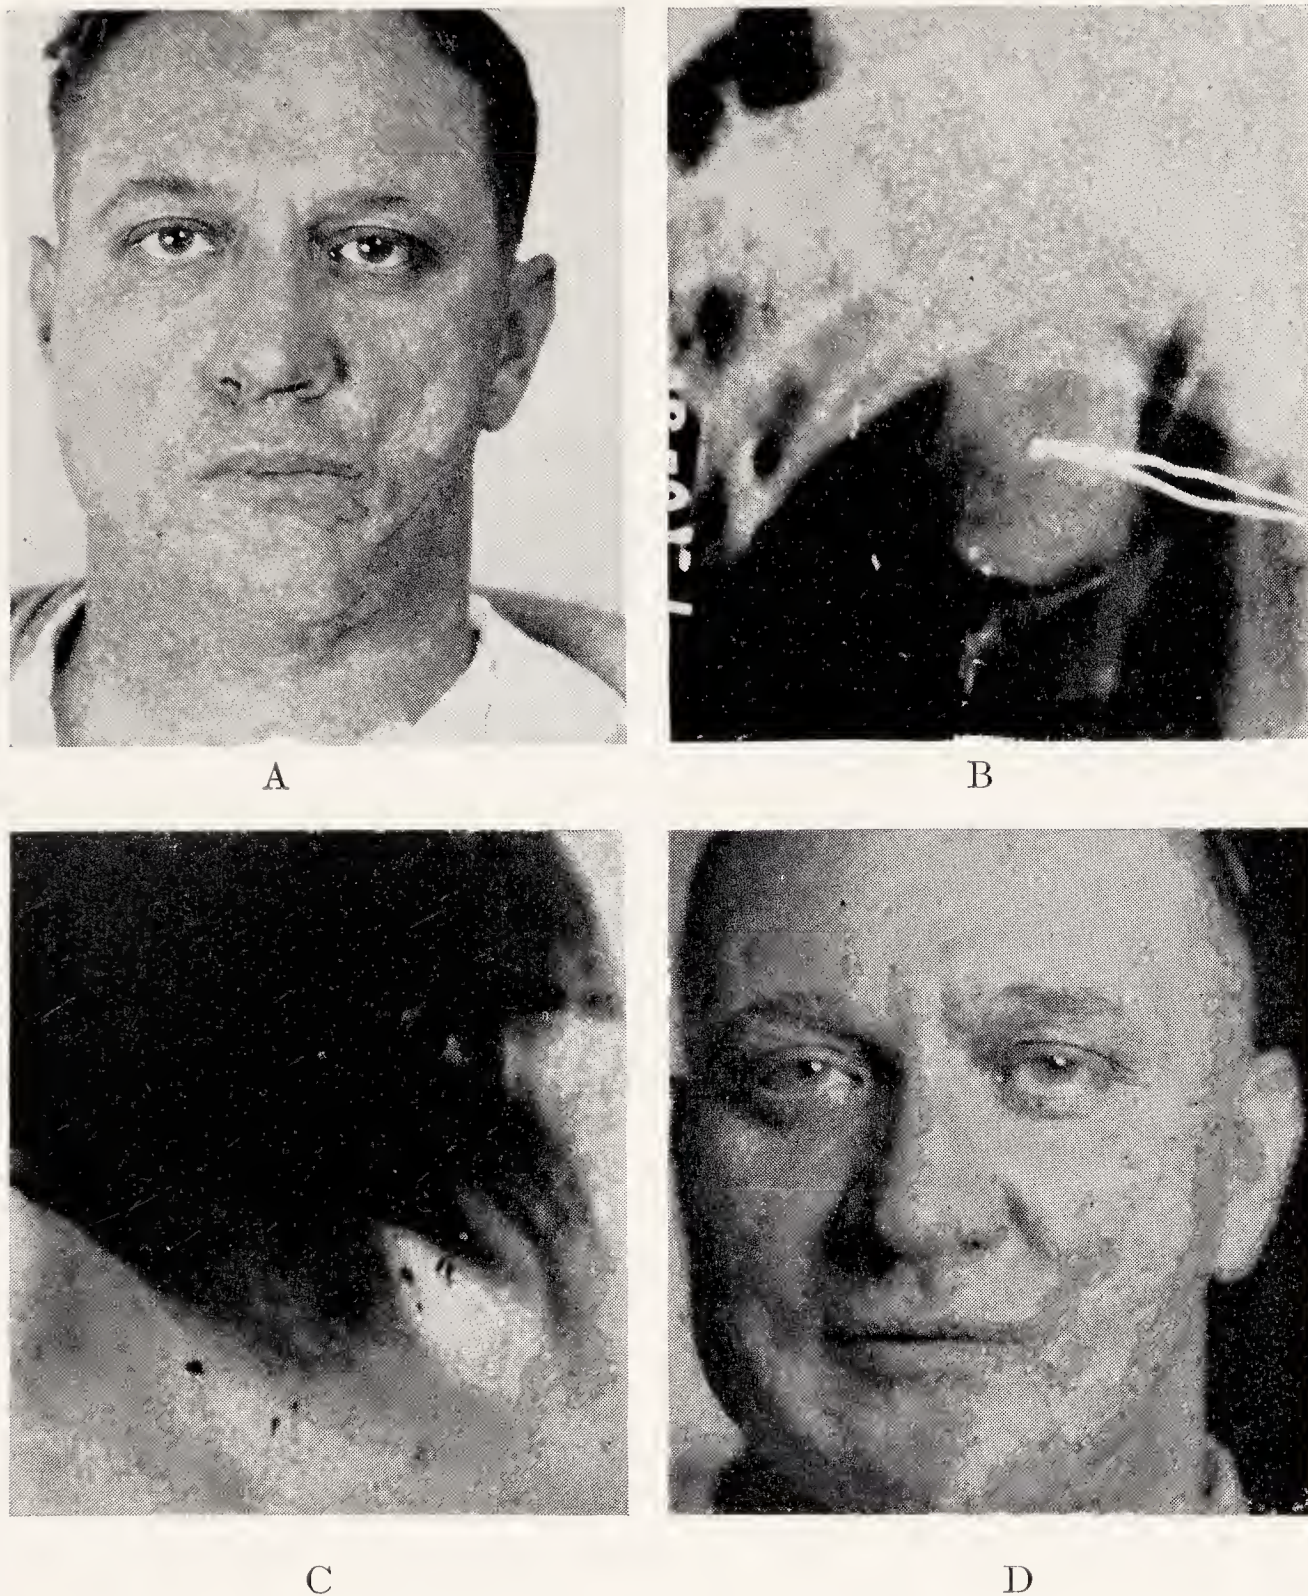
Case of successful bone graft to the body of the mandible. A. Patient before operation. In this case a skin flap was turned in from the neck to give a lining and the butt end of the flap was used for additional covering for the cheek. The ramus of the jaw had been pulled forward so it was pulled back into position by a wire in a projection in a head cast as shown in B, before the bone graft was placed. C. Piece of seventh rib was inserted into the defect and held by heavy kangaroo tendons and careful suturing about the bone graft. This roentgenogram was taken one year after bone transplant. D. Shows external appearance. This bone graft has been in place now since 1934. The man is seen occasionally and he has perfect function and has had no trouble.
